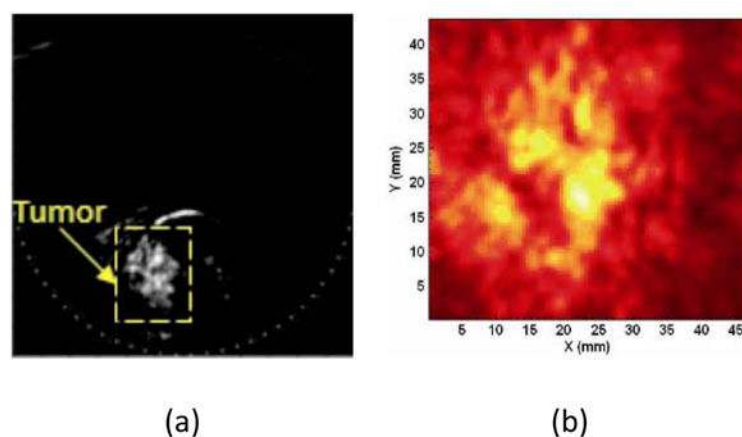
In vivo* photoacoustic computed tomography of the human breast acquired at 1064-nm laser wavelength
